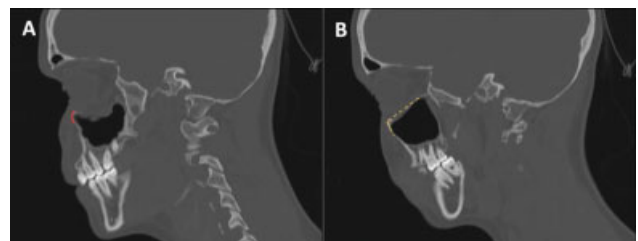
CT scan demonstrating fractured (A) and unaffected contralateral orbit (B). 3D printed footplate is customized to the contour of the patient's anterior orbital rim (red). The angle formed by the intact orbital floor and anterior rim (dashed yellow) determines optimal retractor angle setting.
